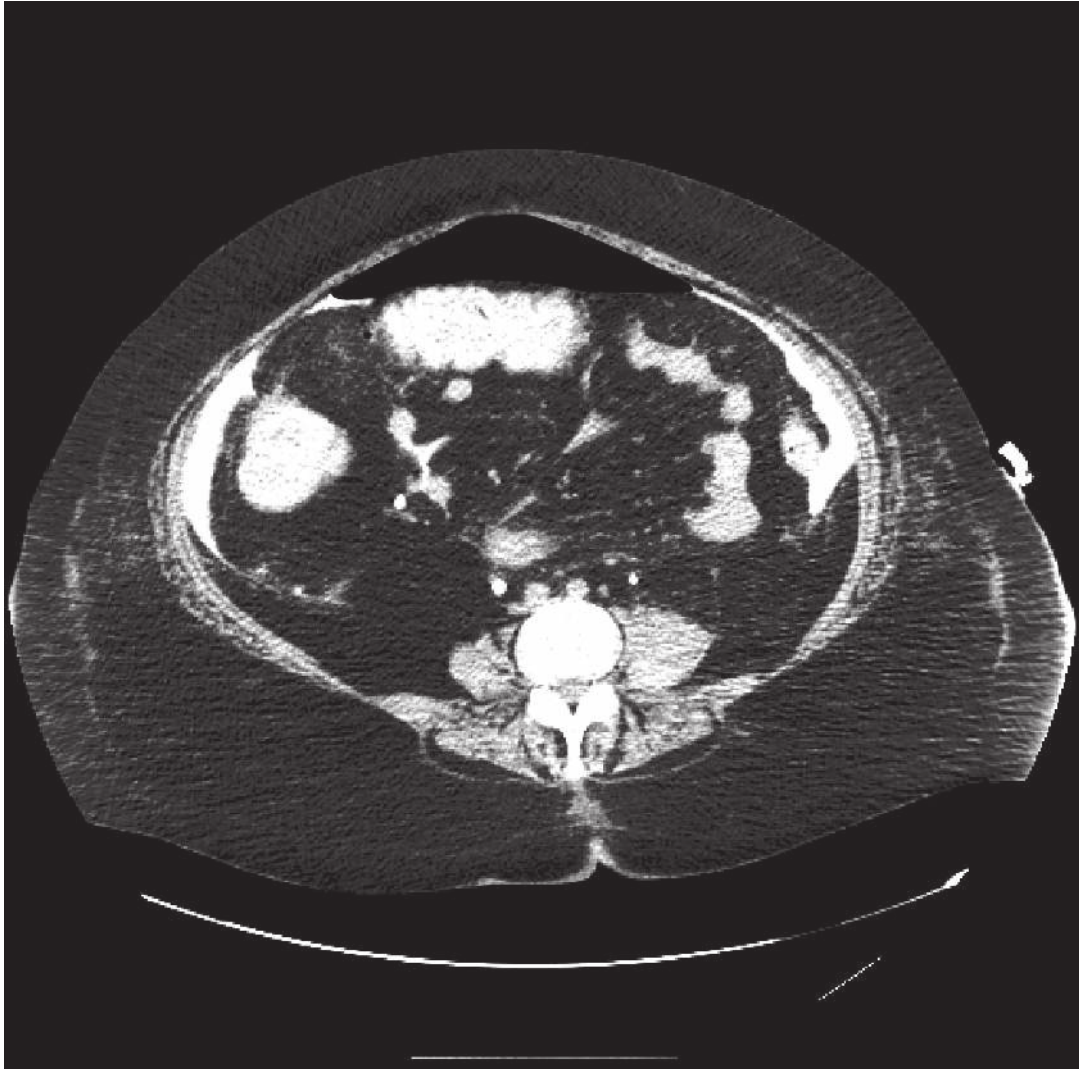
CT OF ABDOMEN SHOWING PERFORATED VISCUS
